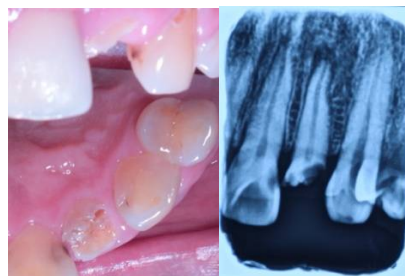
a. clinical view, b. periapical radiograph #22
